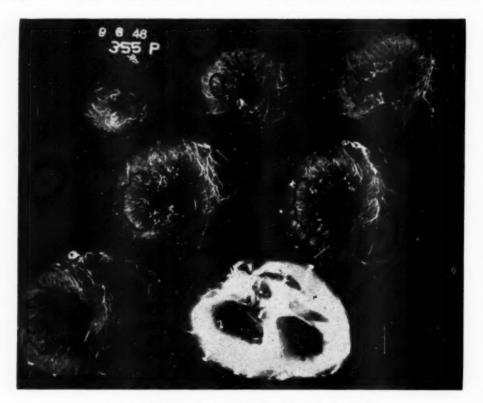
Roentgenogram of the injected heart in Case 145.
